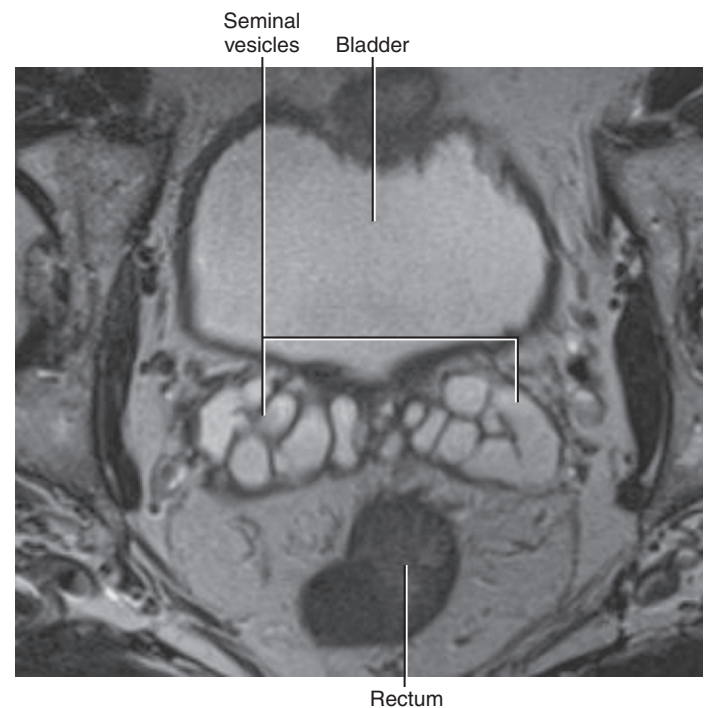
Magnetic resonance imaging (MRI) study, axial transverse section, showing the relationship of the seminal vesicles to the bladder and rectum. (*Image courtesy of Raj Paspulati, M.D.*)
